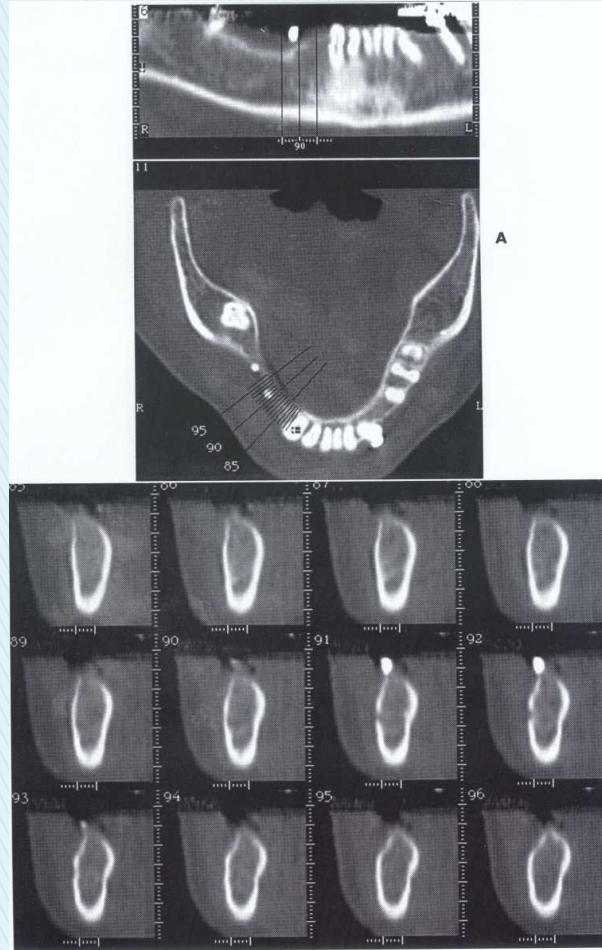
Reformatted axial, coronal, and sagittal cone-beam CT images to assess the viability of an osseous graft before implant placement.
